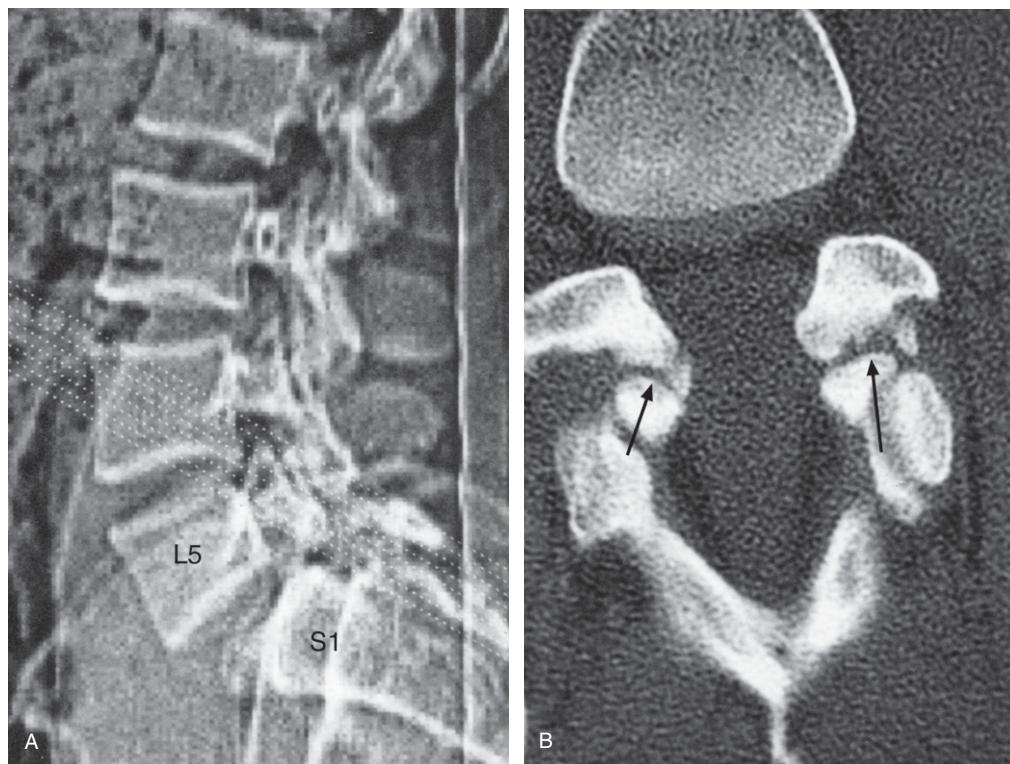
(A) Lumbar spine CT lateral scout image showing the reverse gantry angle CT scans (broken lines) through the pars interarticularis of L5. (B) Lumbar spine CT reverse gantry angle image at L5-S1 clearly demonstrating the bilateral L5 pars defects (arrows) with sclerotic margins reflecting longstanding pathology. A 'pseudodisc' appearance secondary to the spondylolisthesis was reported (white arrows).
